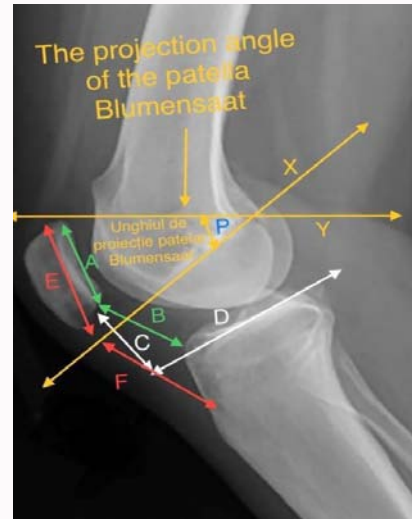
Profile radiography of the knee allows the diagnosis of Patella Alta by the assessment of the following indices: Insall-Salvati Ratio $ISR = F/E$; $N = 0.8 - 1.2$
